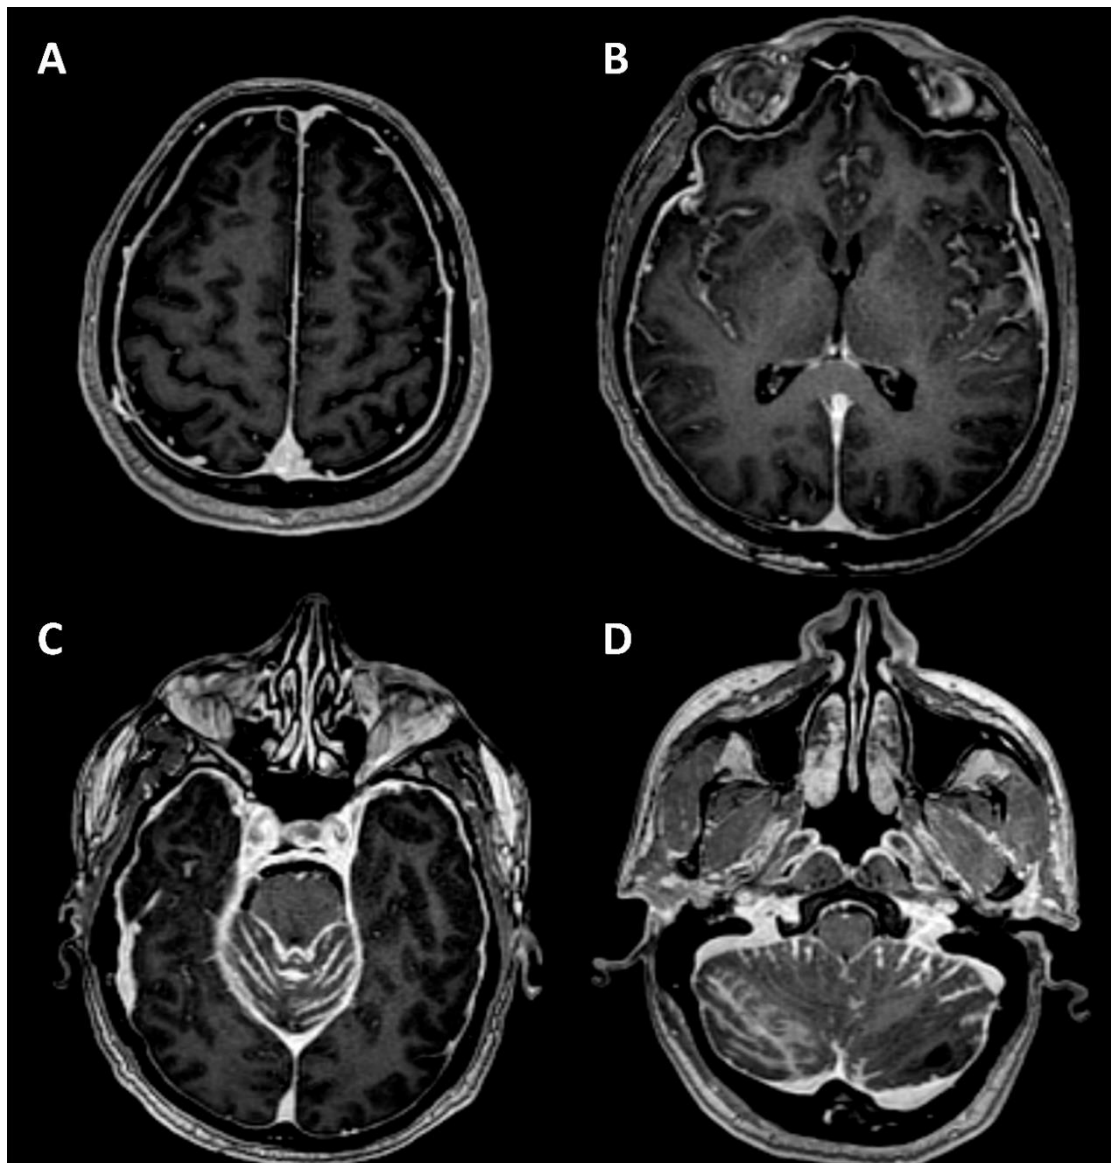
A, B, C: T1-weighted gadolinium-enhanced MRI scan showing brain meningeal enhancement with involvement of the subarachnoid space; D: T1-weighted gadolinium-enhanced MRI scan showing cerebellar and bulbar meningeal enhancement.
